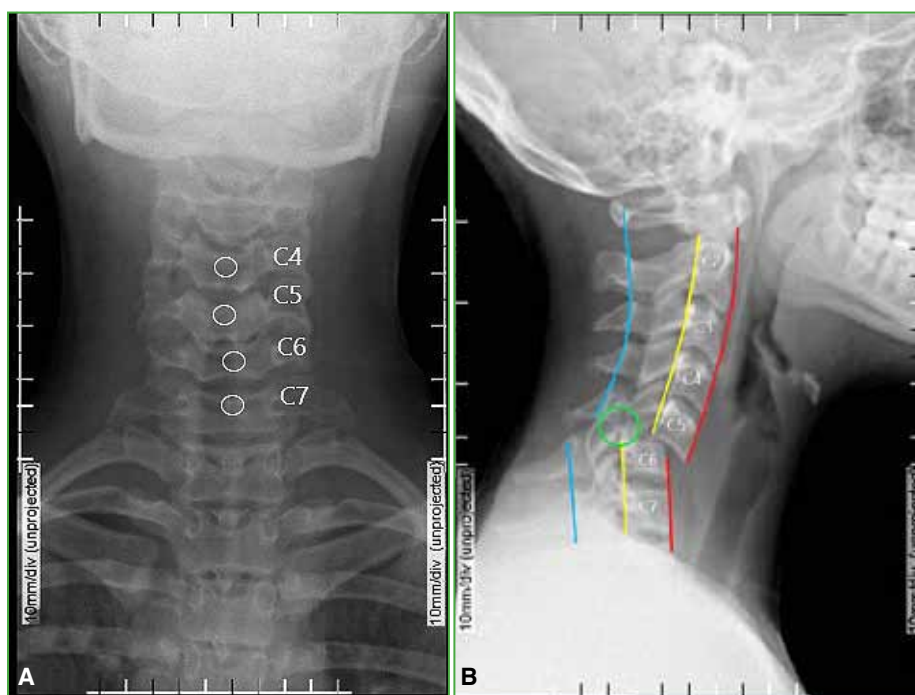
Cervical spine radiographs. A. Anteroposterior. Loss of continuity of the three lines (anterior, posterior, and spinolaminar) at C5-C6 with overlapping of the facets of C5 on C6 (circle). B. Lateral. Bilateral facet dislocation. Enlargement of the space between the C5-C6 spinous processes with loss of normal alignment. No evidence of fracture lines. No visible fractures.
